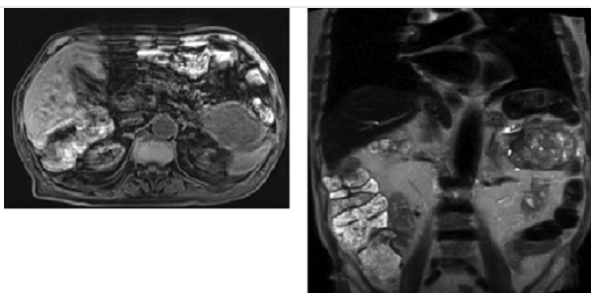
Abdominol MR image 2
